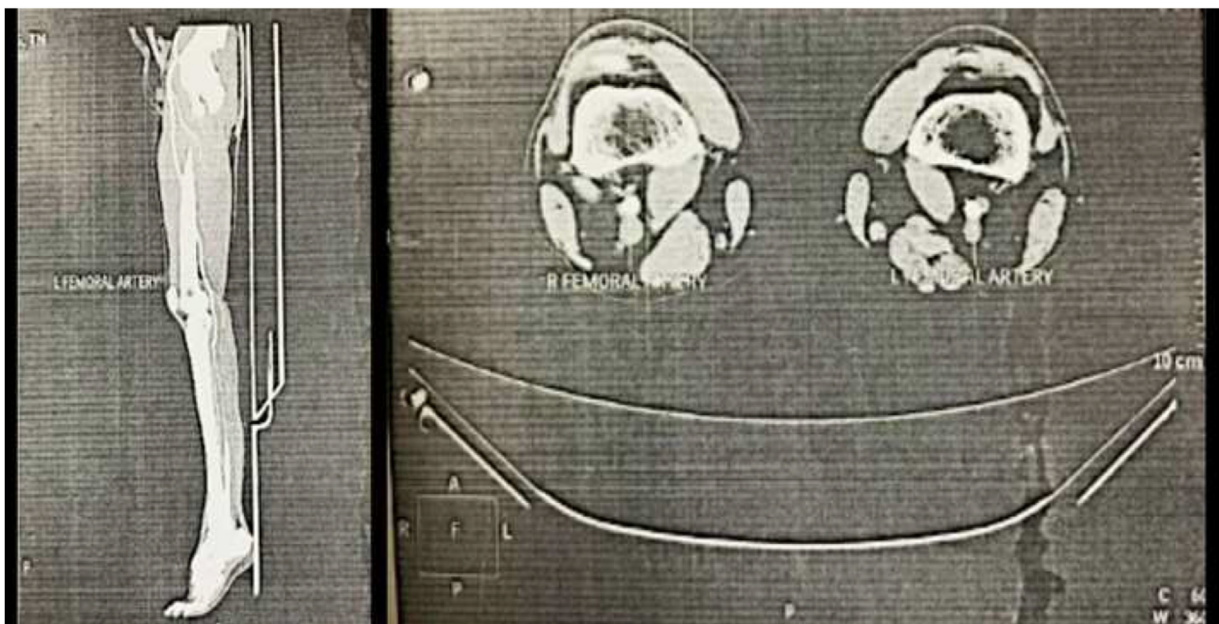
CT Angiography resulted in normal muscular and skeletal structures without vascular abnormality features.
